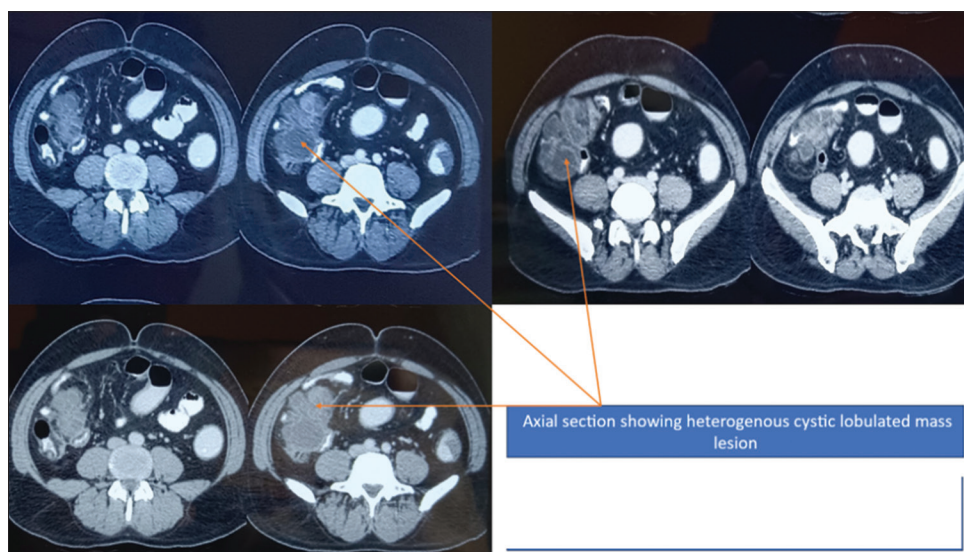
Axial section of contrast-enhanced computed tomography abdomen showing mass in the right iliac fossa
